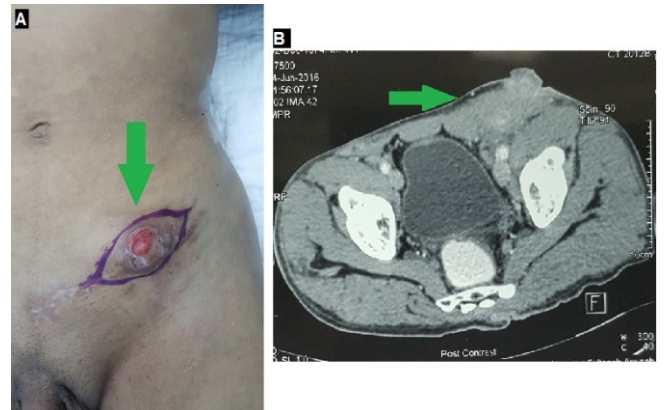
A. Pre-operative marking of the fungating mass over the left inguinal region (green arrow). B. CT abdomen with fungating mass (green arrow) infiltrating the surrounding subcutaneous and abdominal wall muscle.
